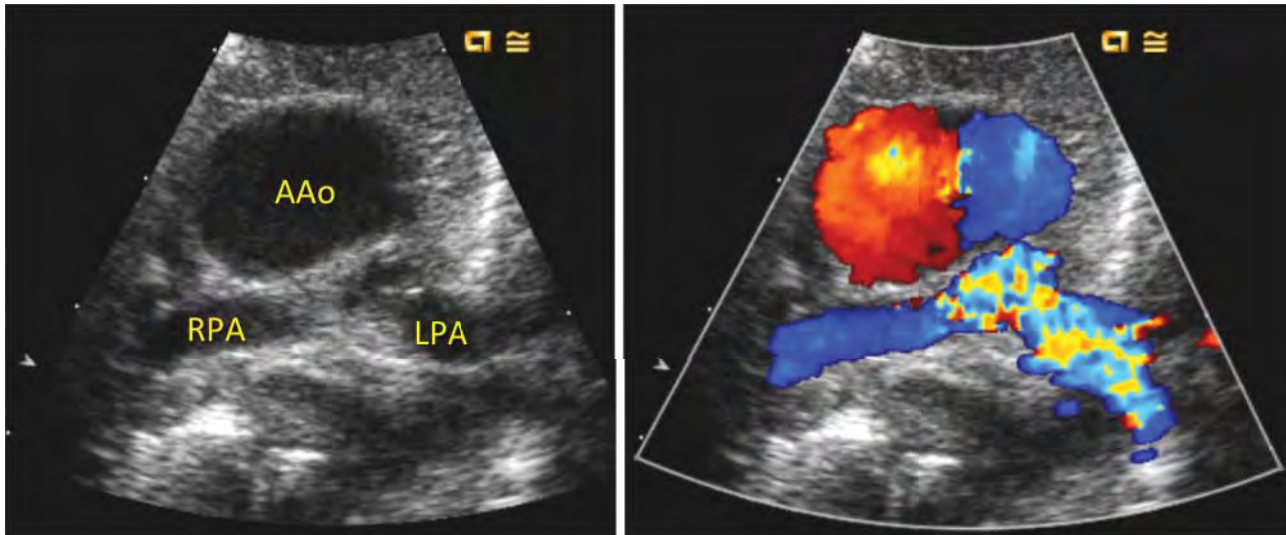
High parasternal short-axis view showing the confluence of the branch pulmonary arteries. AAo, ascending aorta; LPA, left pulmonary artery; RPA, right pulmonary artery.
